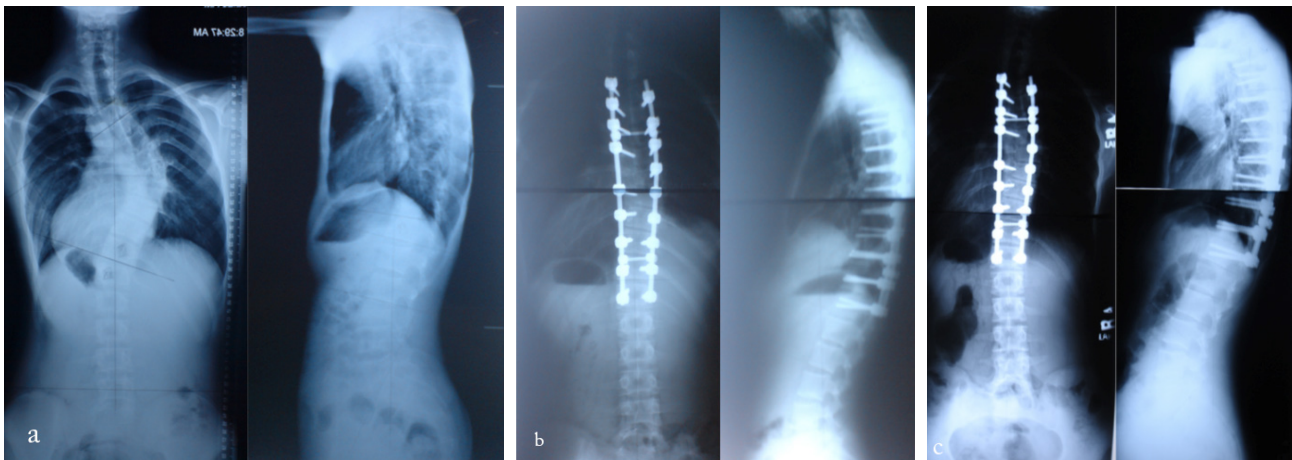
a) preoperative, b) postoperative, and c) last follow-up radiographies of 13 years old male. Thoracic major curvature was corrected from 50° to 9° with a 82% correction rate. At the final follow-up on 125th month, 2 % correction loss was seen.
